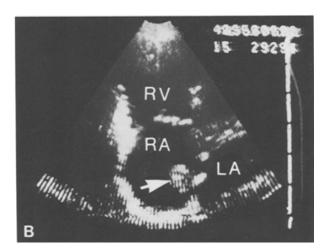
Echocardiography in right atrial myxoma. A A dense cloud of echos behind the tricuspid valve is seen on this M-mode echocardiogram. B Two-dimensional echocardiogram in the truncated apical view of the right atrial myxoma (arrow).
